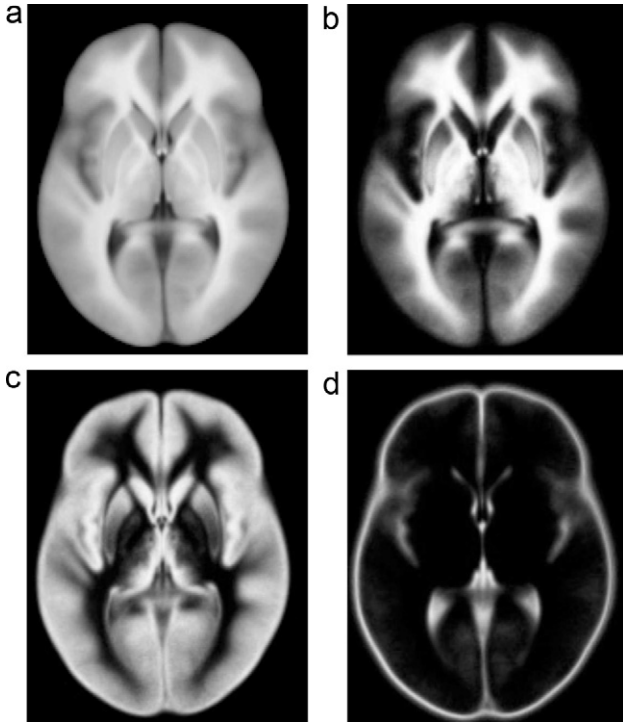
ICBM452 population-based atlas [27]: (a) T1-weighted mean, (b) white matter, (c) grey matter, and (d) cerebrospinal fluid.
